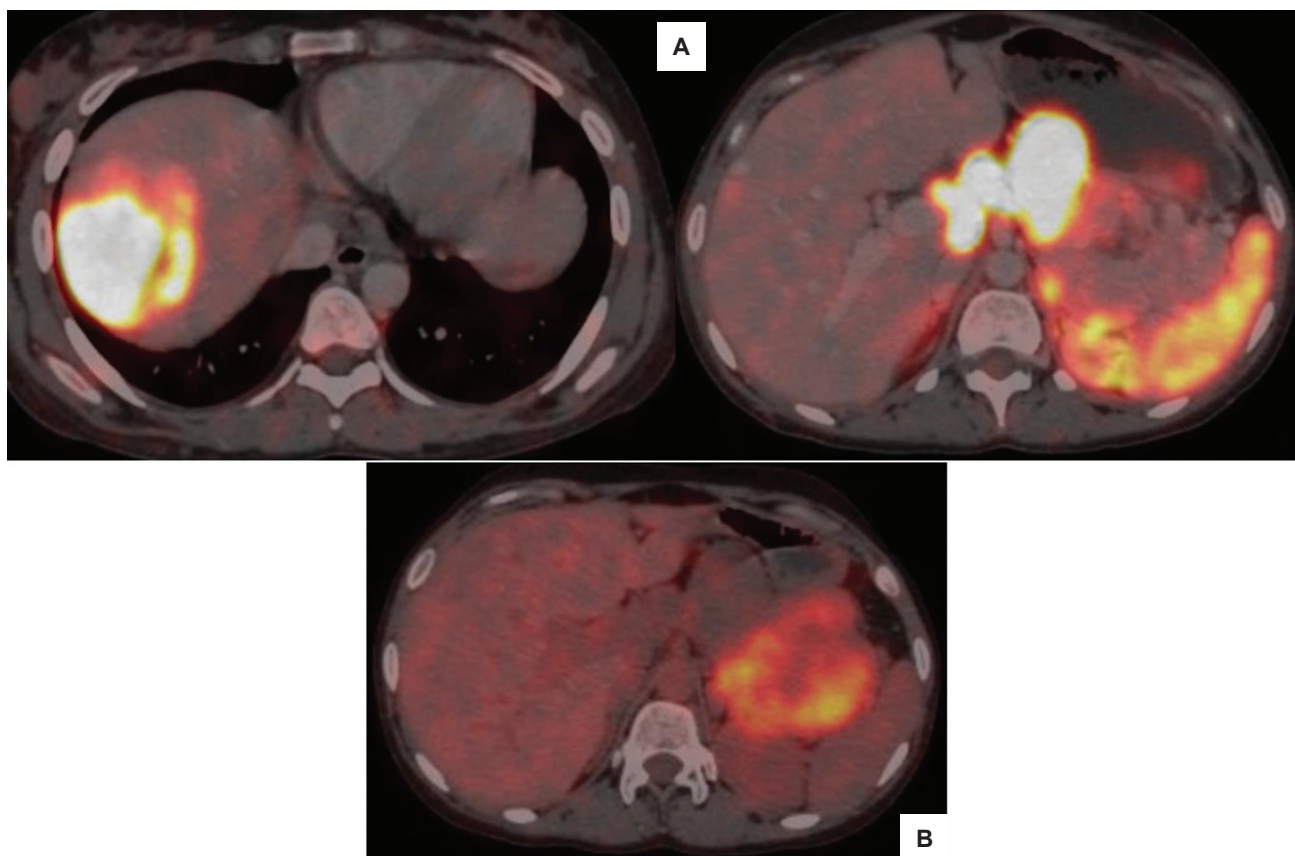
(A) ⁶⁸Ga DOTATATE PET/CT image before surgery shows avid uptake seen in segment 8 of liver and pancreatic head and body; (B) ¹⁸F-FDG-PET/CT image before surgery shows uptake is present in mass in tail of pancreas.
